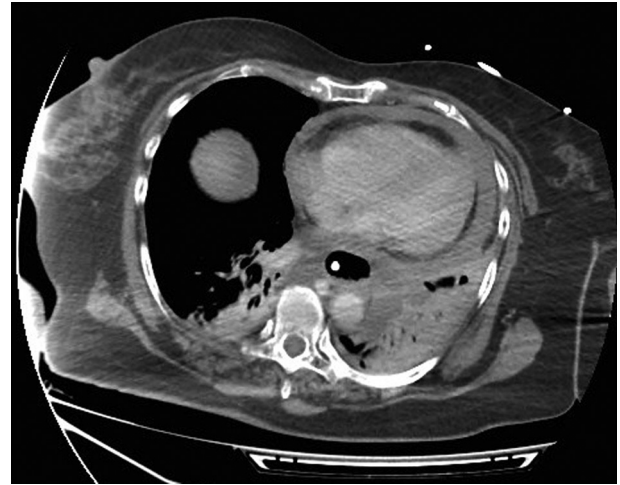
CT-scan showing a bilateral pleural effusion and a large pericardial effusion causing the collapse of the right atrium and ventricle.
